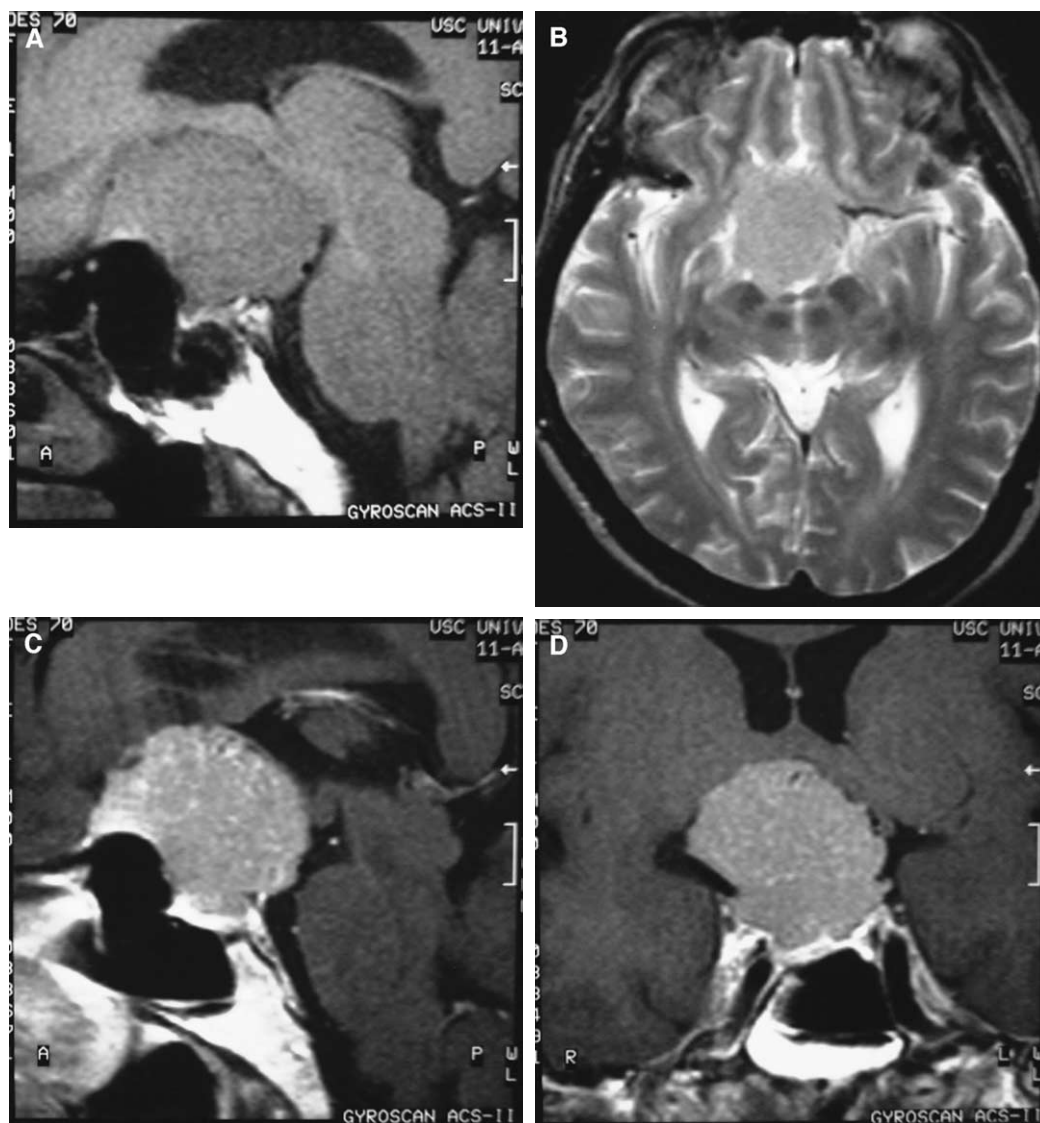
Suprasellar meningioma. (A) Sagittal T1-weighted image shows a large suprasellar isointense mass with subfrontal extension. (B) Axial T2-weighted image shows the mass to be isointense to gray matter. (C) Sagittal postcontrast T1-weighted image shows homogeneous enhancement of the mass. The pituitary gland is seen inferior to the mass and demonstrates more contrast enhancement. (D) Coronal postcontrast T1-weighted image demonstrates enhancement of the suprasellar mass.
